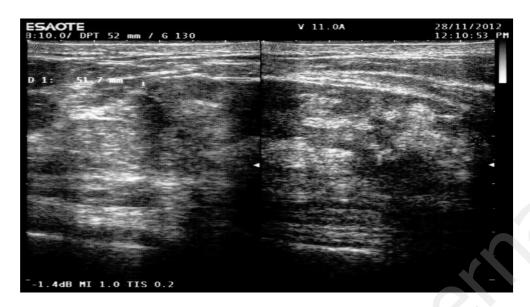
Ultrasound. The lesion is well-capsulated.
